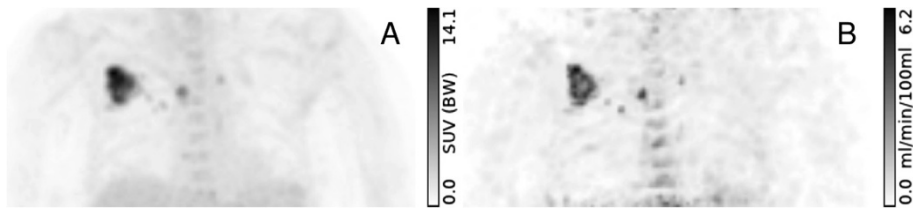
Comparison of parametric images of SUV and $K_s^{(c)}$. (A) FDG SUV 67 min. p.i. and (B) parametric $K_s^{(c)}$ map in a 63-year-old woman. The patient has a bronchial carcinoma of the right lung and lymph node metastases of the right hilar region and the mediastinum (coronal maximum projection). Note the different regional contrast and the used units in both images.
